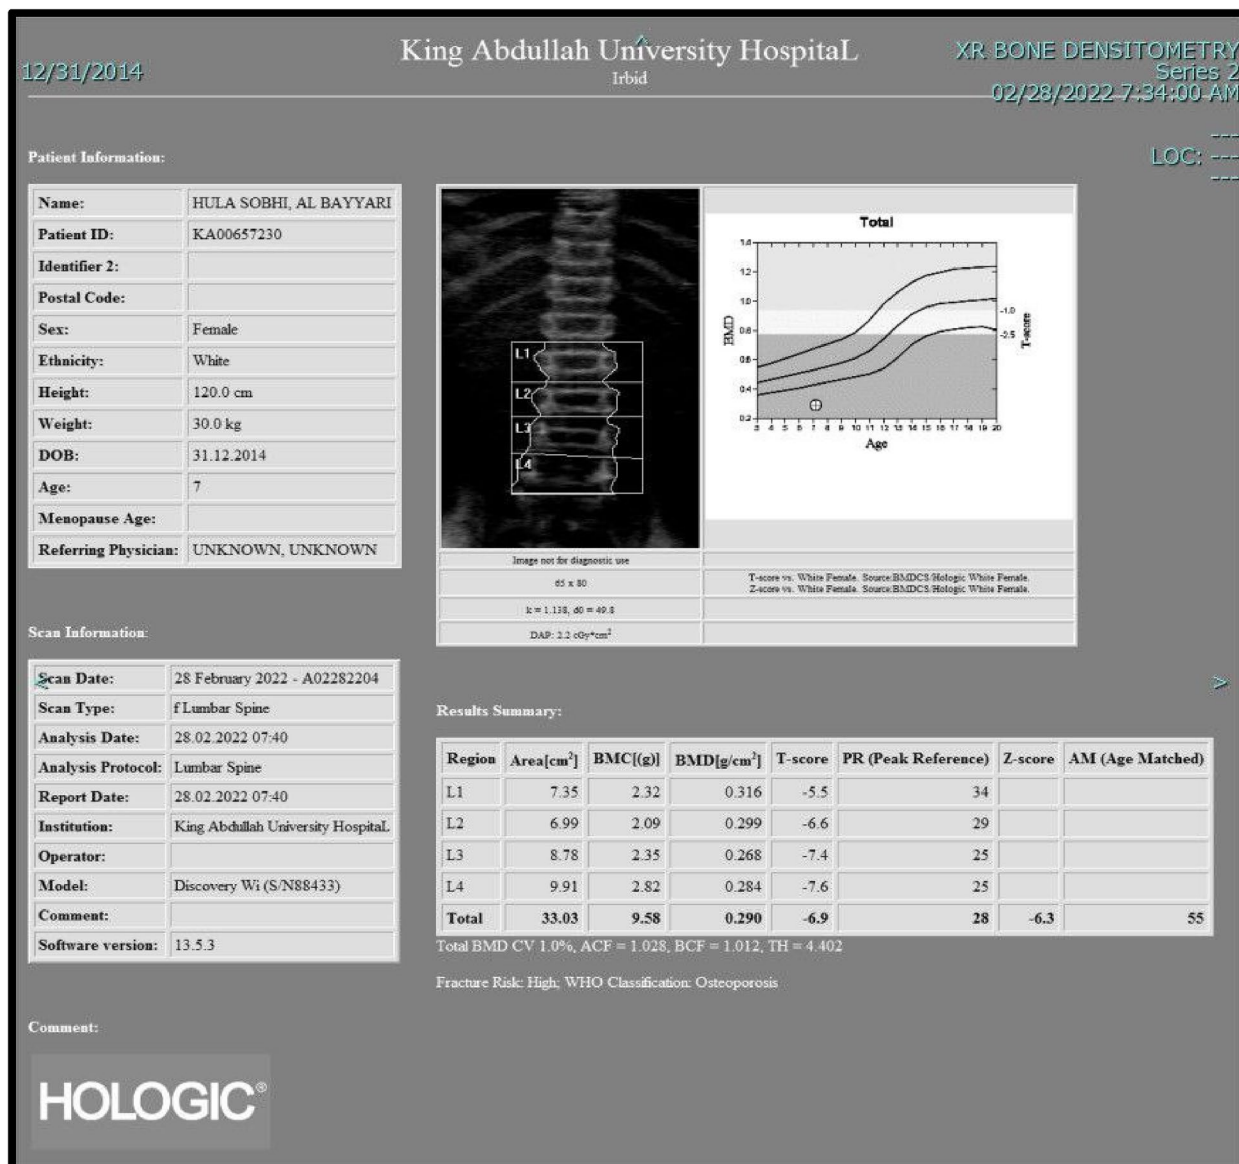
DEXA (dual X-ray absorptiometry, z-score (-6.3)
